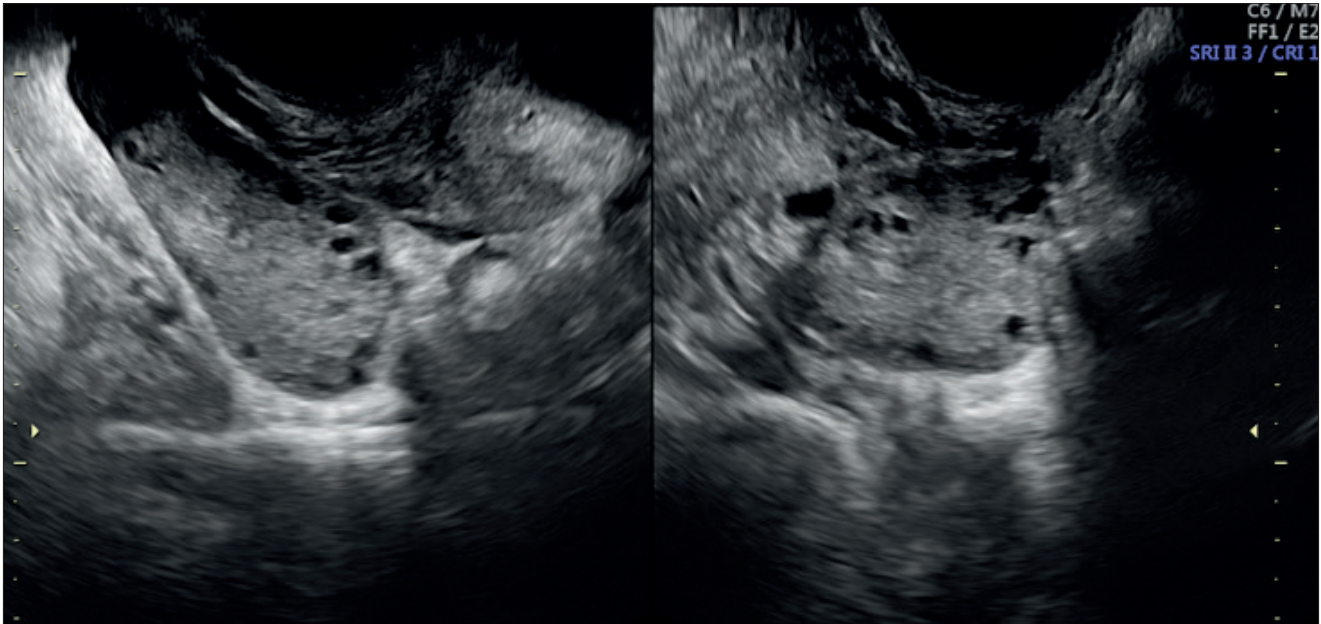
Ultrasound after adnexal detorsion: the ovary shows normal size, morphology, location and vascular flow.
